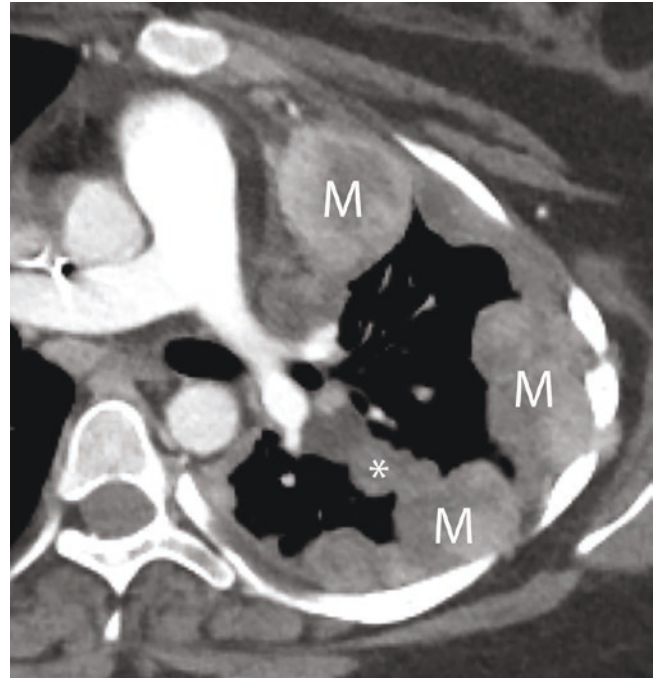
Pleural metastasis from synovial sarcoma. Contrast-enhanced axial CT with gluteal synovial sarcoma with multiple large heterogeneously enhancing pleural metastases (M) with additional fissural metastasis (*)
